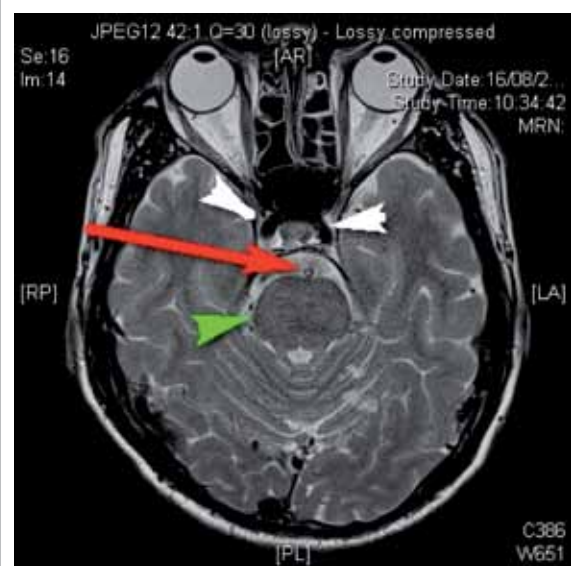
An axial T2-weighted turbo spin echo image of the brainstem shows loss of flow void at the basilar artery (red arrow). Note the normal flow void (dark) bilateral cavernous portion of the internal carotid arteries (white arrowheads). No abnormal signal was detected at the pons (green arrowhead)
